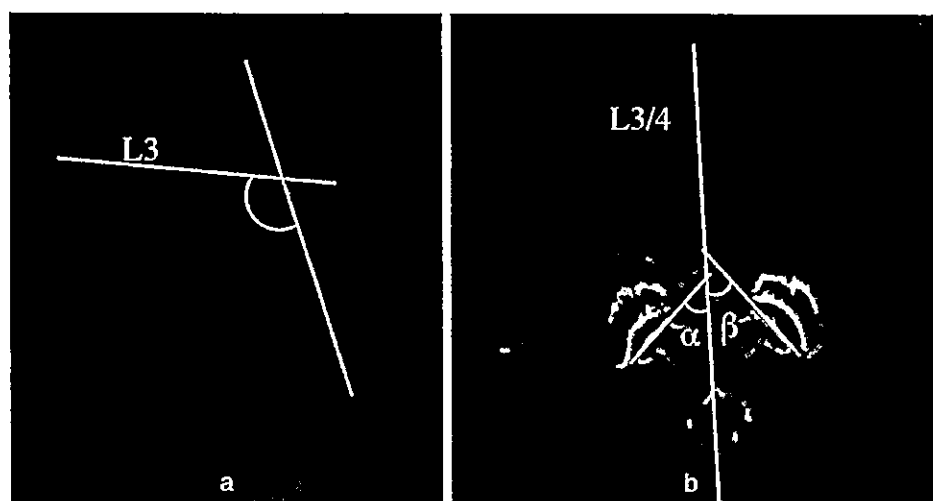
a* The laminar inclination angle at L3 was defined as the angle formed by a *straight line* connecting the base of the superior facet with the base of the inferior facet, and a *straight line* connecting the midpoints of the anterior and posterior L3 vertebral cortices on lateral radiographs. *b* Facet orientation and tropism were determined by
